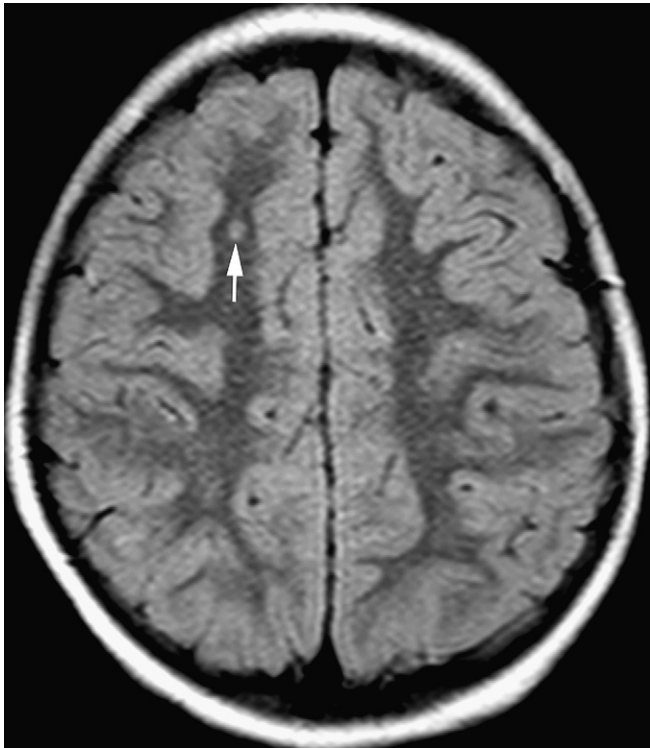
Brain MRI: axial FLAIR MRI shows small hyperintense area in the subcortical white matter of the right frontal lobe (arrow).
